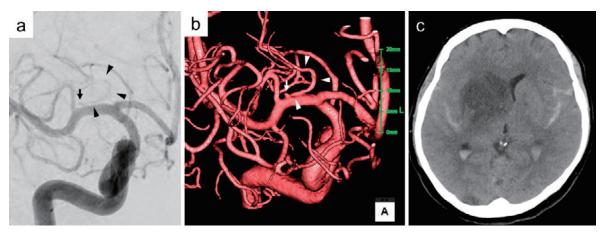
(a) Right internal carotid angiogram, anteroposterior, and (b) three-dimensional angiogram on the day after onset, which shows the disappearance of the sac of the middle cerebral aneurysm and a tiny protrusion (arrow) and lateral lenticulostriate artery (arrowheads) at the right middle cerebral artery. (c) Noncontrast head computed tomography on the day after onset, which indicates an ischemic or edematous lesion at the right basal ganglia.
